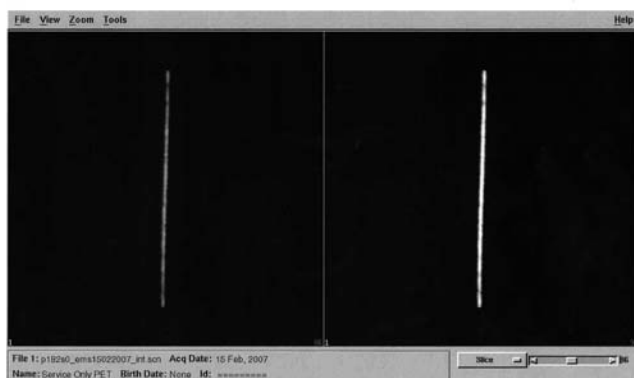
An example of a daily QC sinogram acquired on a Philips Gemini PET/CT using a ^{22}Na source (courtesy: L. Indovina and A. Giordano, Catholic University, Rome).
